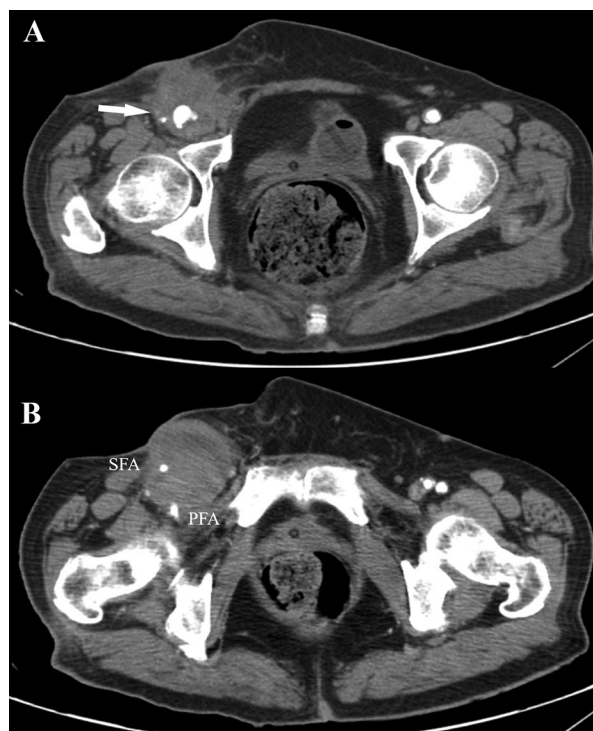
CT shows large common artery pseudoaneurysm. A — CT scan at the level of CFA (arrow shows CFA with visible leakage of contrast); B — CT scan at level of 1–2 cm below the division of CFA into SFA and PFA (massive aneurysm shifts both femoral arteries to the side)
